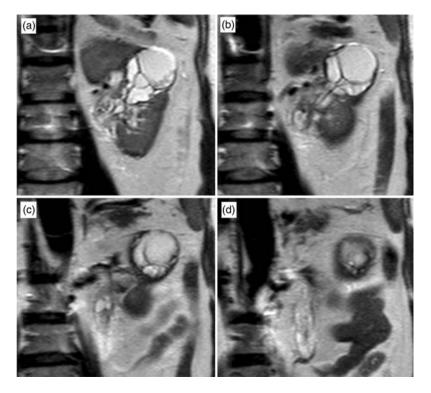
(a, b, c, d) Continuous slices of coronal T2-weighted MRI showing a well-circumscribed multiseptate cystic mass with a polypoid compartment extending into the renal pelvis and proximal ureter
